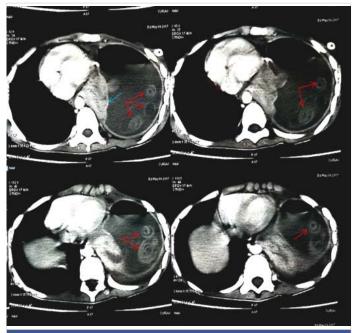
Computed tomography chest showing hydatid cyst with its membranes and daughter solices and collapsed lung.
